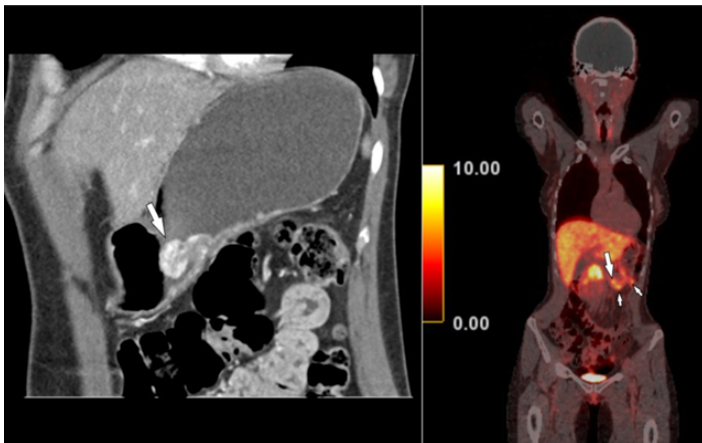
Left: Contrast-enhanced MDCT (paracoronaral 3D-reconstruction) of the stomach demonstrates a polypoid hypervascular mass at the greater curvature (arrow). Right: subsequent somatostatin receptor analogue PET/CT shows not only the hypermetabolic mass in the stomach (large arrow), but also two metastatic lymph nodes outside the stomach (small arrows).
